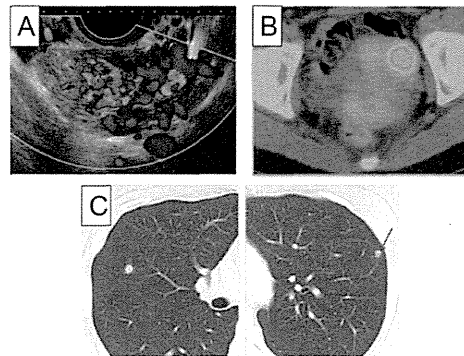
Imaging findings. (A) Transvaginal Doppler ultrasound results show extensive vascularization within the myometrium. (B) A PET/CT image reveals increased FDG uptake in the mass. (C) A CT image shows multiple nodules in both lungs.
